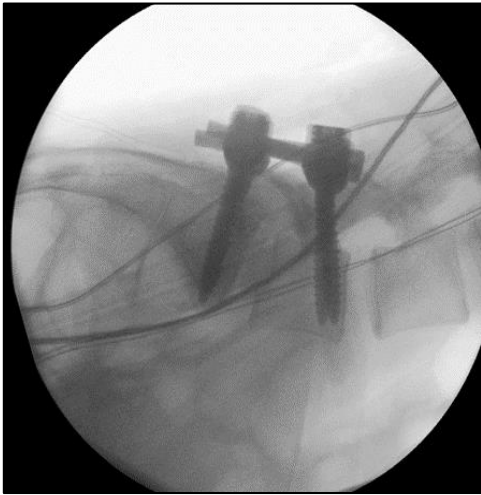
Intra operative radiograph after TLIF – lateral view
